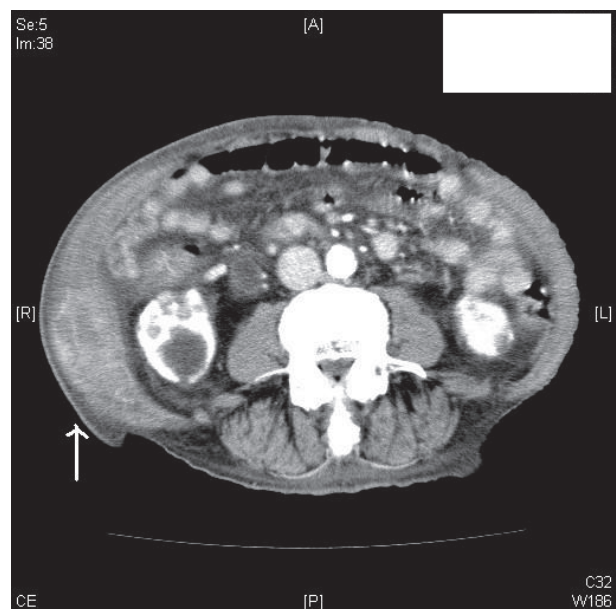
Transverse contrast CT scan of abdomen showing a haematoma in right lateral abdominal wall (arrow).
